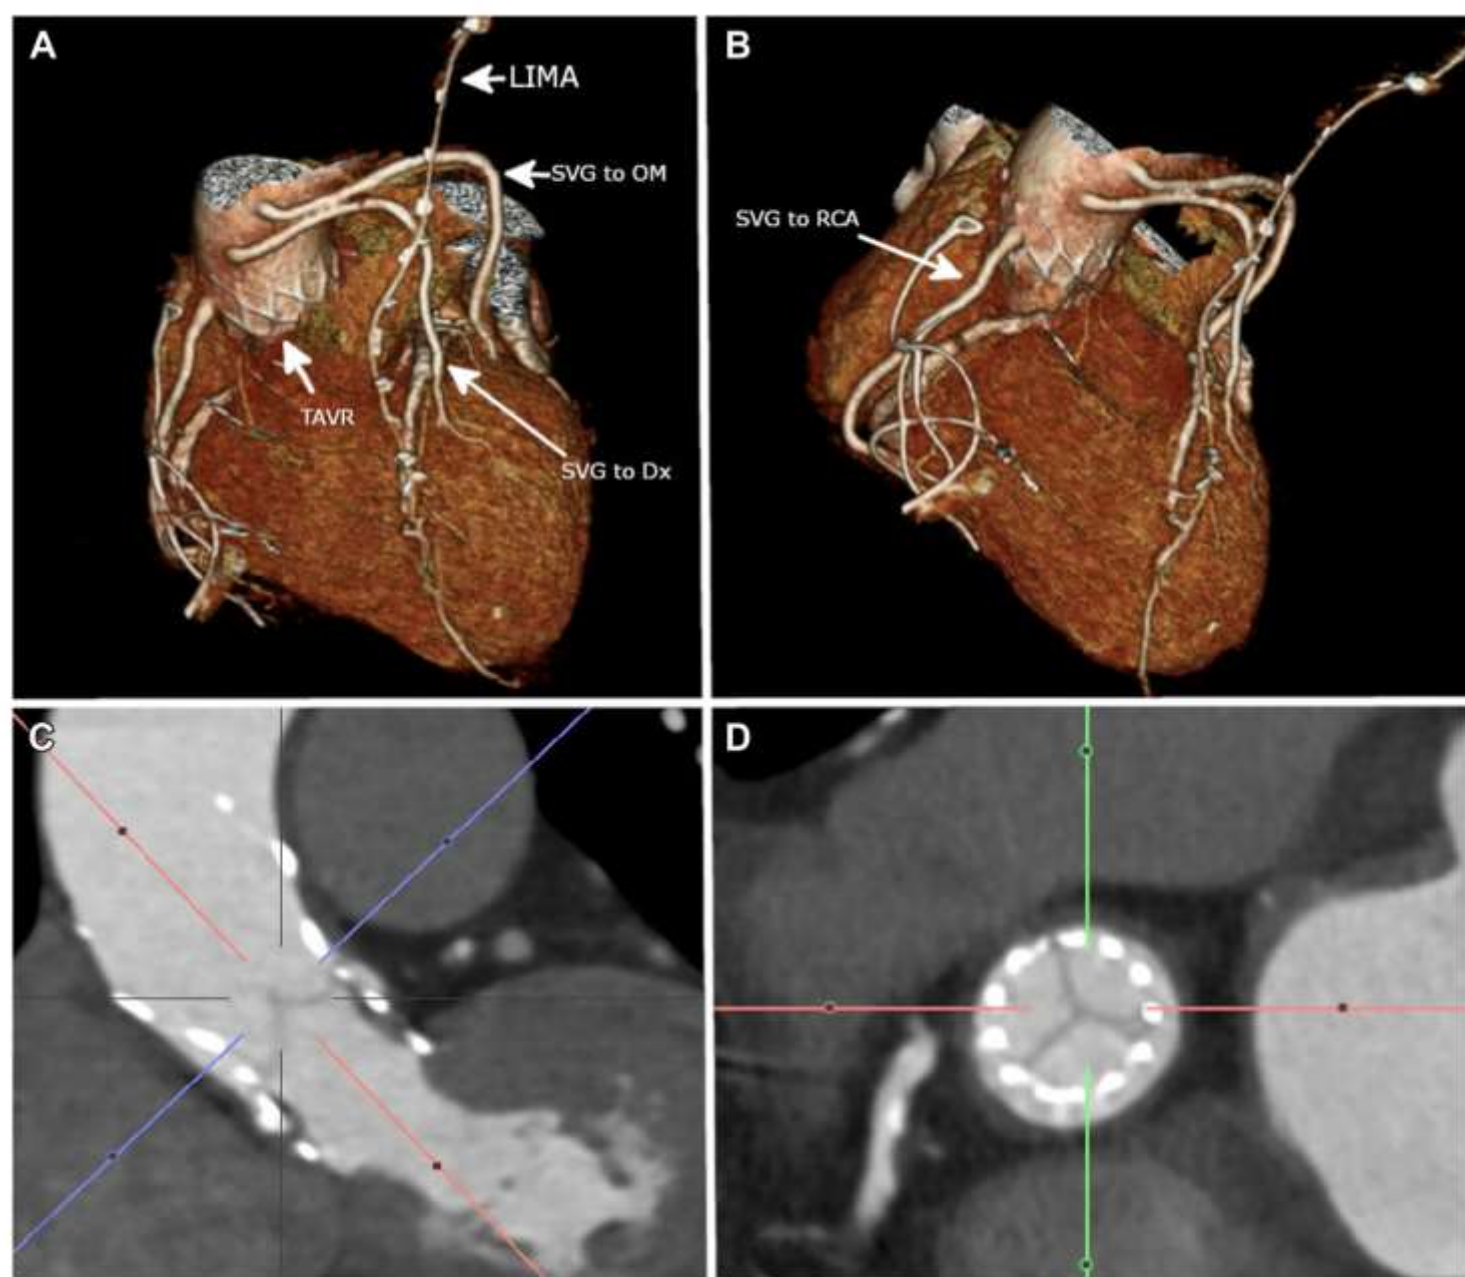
coronary artery bypass graft (CABG) evaluation of graft patency: Cardiac computed tomography angiography (CCTA) of a patient post transcatheter aortic valve replacement (TAVR) and CABG x 4. Patency of grafts (LIMA to LAD, SVG to Dx, SVG to OM, SVG to RCA) are all identified. CCTA allows the additional benefit of evaluating the prosthetic valve for thrombosis, which was ruled out on this exam. Dx, diagonal branch (coronary artery); LAD, left anterior descending (coronary artery); LIMA, left internal mammary artery; OM, obtuse marginal (coronary artery); RCA, right coronary artery; SVG, saphenous vein graft.
